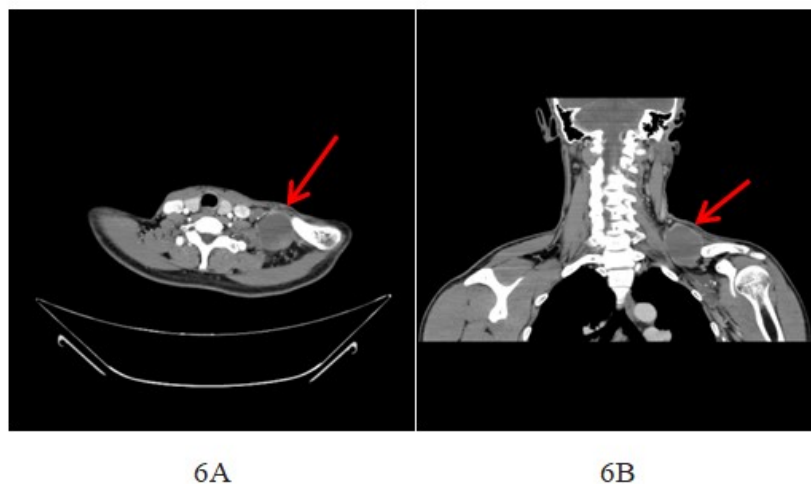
~B: Male, 49 years old. (A) Axial position. (B) Coronal position. Left neck mass (arrow), cystic hypodense shadow, CT after direct lymphangiography, iodized oil residue was seen in the left venous angle area, left neck, left subclavian to axillary.
